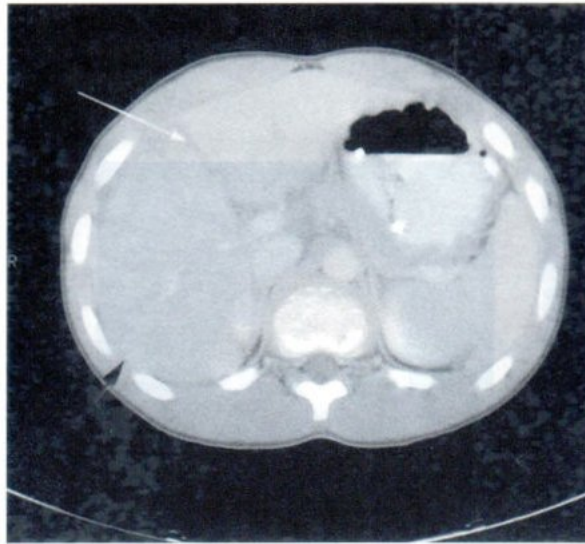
Computed tomography (CT) of the patient after trauma showed liver laceration adjacent to the falciform ligament (white arrow) and hemoperitoneum (thin layer surrounding the liver, black arrow)
